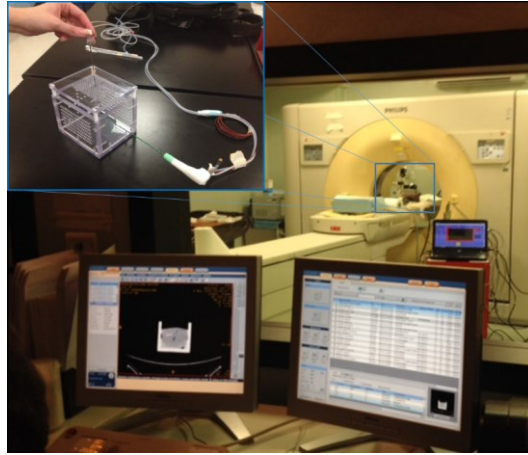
Experimental setup for MTA study conducted under CT control. Top-left: detail of the purposely developed box.
